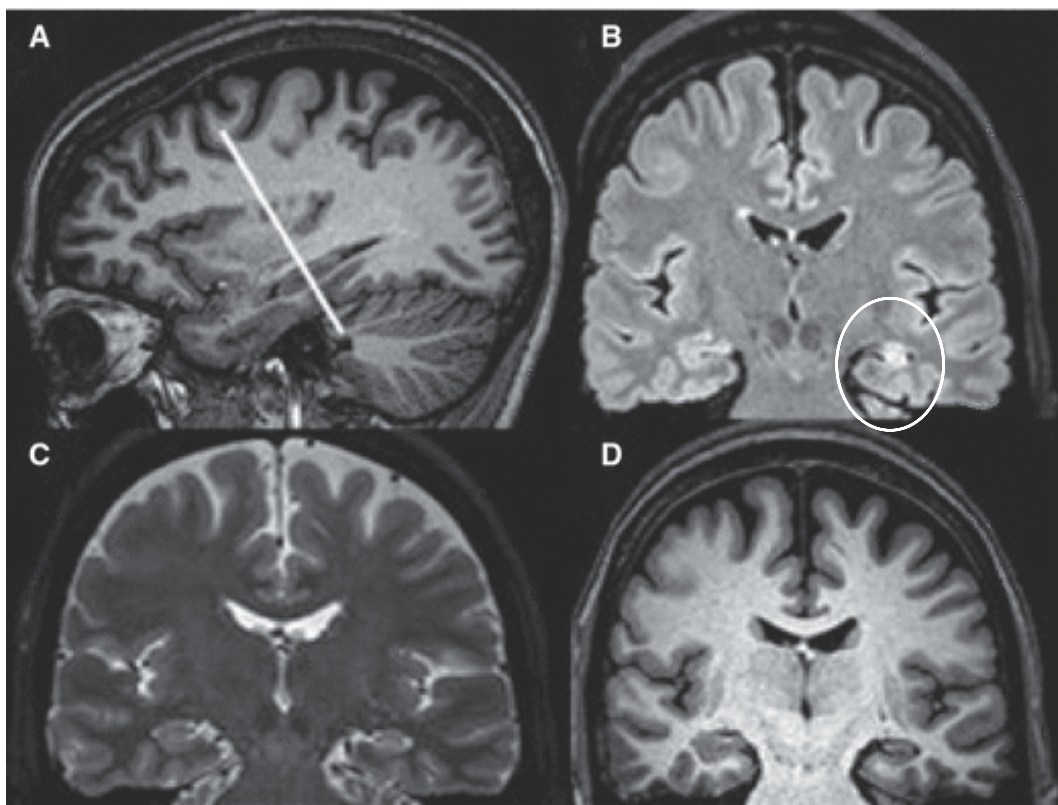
Left hippocampal sclerosis at MRI. (A) Sagittal T1 image showing a line that indicates the orientation of the coronal images, which are perpendicular to the hippocampus's long axis and correspond to the coronal T1 level in D. (B) Coronal FLAIR image depicting atrophy and increased T2 signal. (C) Coronal T2 image corroborating the FLAIR findings. (D) T1-weighted coronal image. From Malmgren & Thom (2004) (100).
